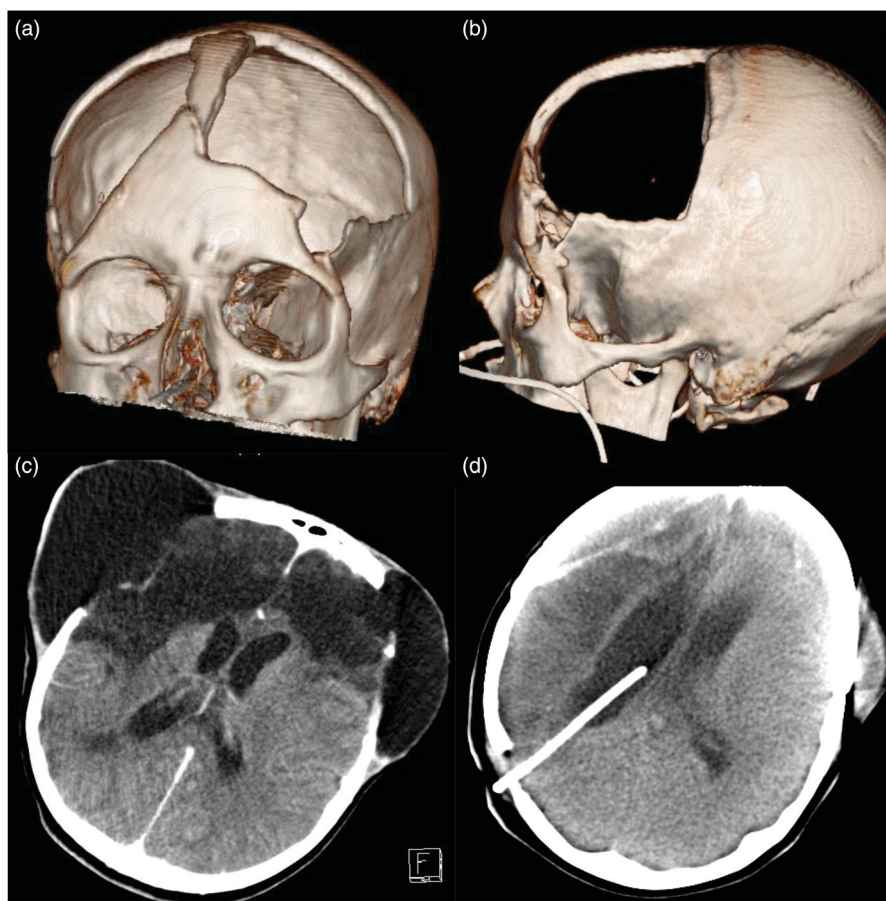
Bi-frontal decompressive craniectomy and external hydrocephalus (images taken 4 months after injury). (a and b) CT 3d reconstruction demonstrating extent of bi-frontal decompressive craniectomy. (c) axial CT demonstrating significant external hydrocephalus prior to shunt placement and evidence of frontal (left) and fronto-temporal (right) gliosis post-injury. (d) resolution of external hydrocephalus post insertion of bi-frontal cranioplasty and ventriculoperitoneal shunt.
